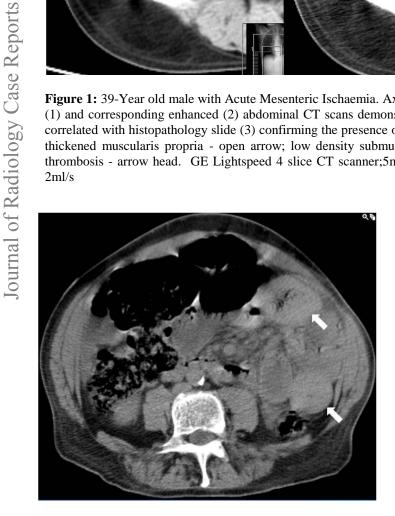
Case 2 was found to have haemorrhagic/ischaemic bowel loops and venous thrombosis at surgery. Unenhanced abdominal CT scan demonstrating dense bowel loops in left mid-abdomen (GE Lightspeed 4 slice CT scanner;5mm slice thickness)
